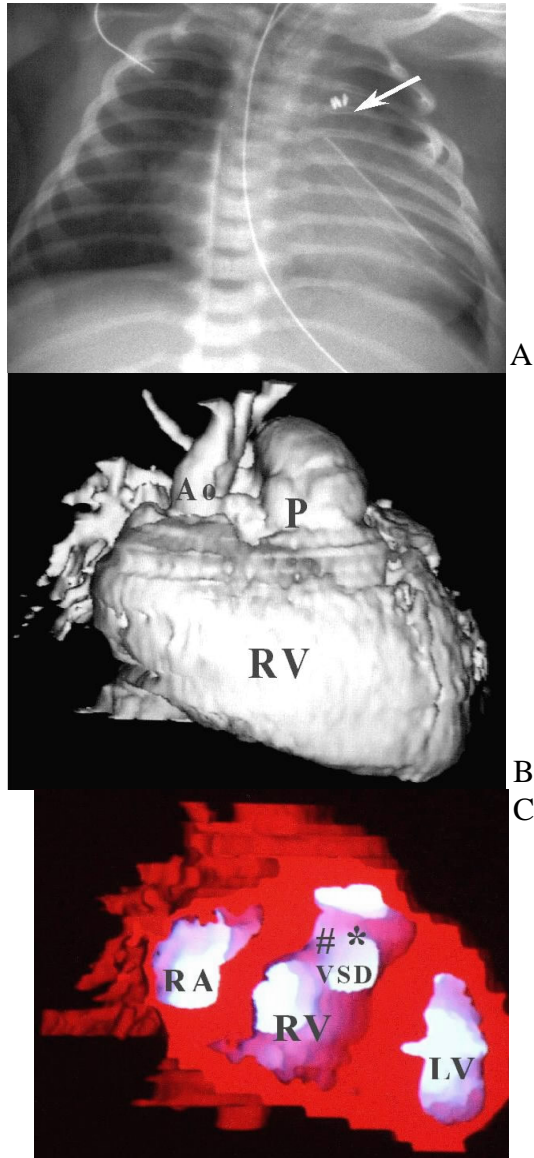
Sub-aortic type VSD of DORV. (A) CXR showed cardiomegaly. The pulmonary segment was engorged (arrow). (B) 3D CTA revealed both PT & Ao arose from the RV with dilated PT located left anterior ( $61^{\circ}$ ) to Ao. (C) 3D inner cardiac view demonstrated the location of the VSD just under the orifice of Ao (#), the conus septum (\*) ran in oblique horizontal plane. Ao=aorta; LV=left ventricle; PT=pulmonary trunk; RA=right atrium; RV=right ventricle; VSD=ventricular septum.
